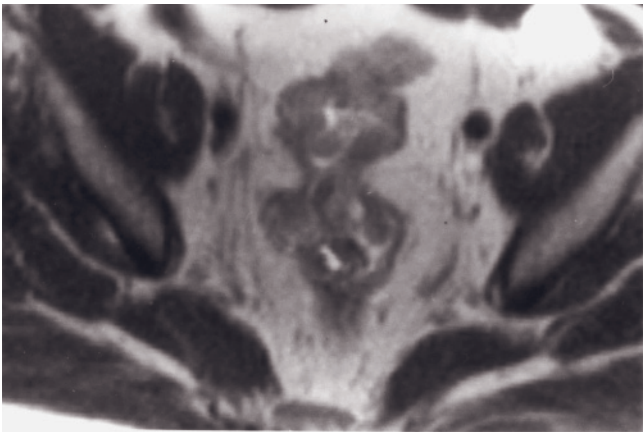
Rectal cancer. Transverse T2-weighted ETSE (*a*) and interstitial-phase gadolinium-enhanced SGE (*b*) images. There is a soft tissue mass involving the wall of the rectosigmoid with gross tumor extension through the left aspect of the wall (arrow, *a*). Small regional lymph nodes are also identified (arrow, *b*). Sagittal postgadolinium SS-ETSE (*c*) and interstitial-phase
